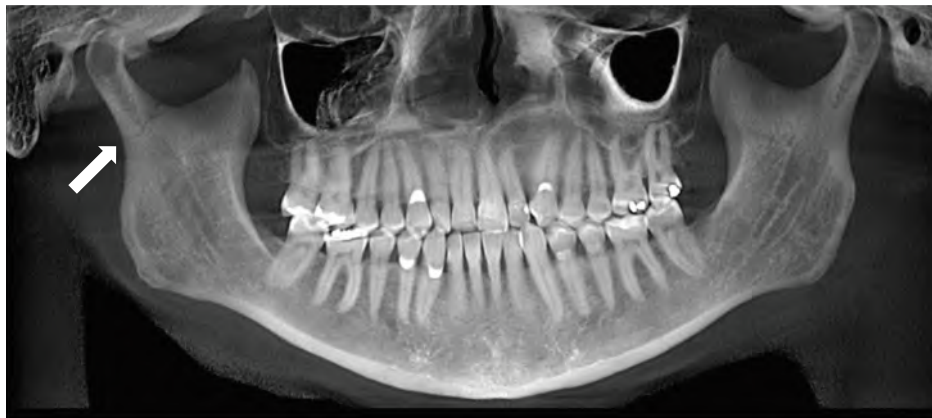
4 Virtual panoramic radiograph shows a nondisplaced fracture through the buccal and lingual cortices of the right condyle. The angle, body, symphysis, and left condyle are intact. (Courtesy of Dr. Jarred Abel, Chevy Chase, MD.)
